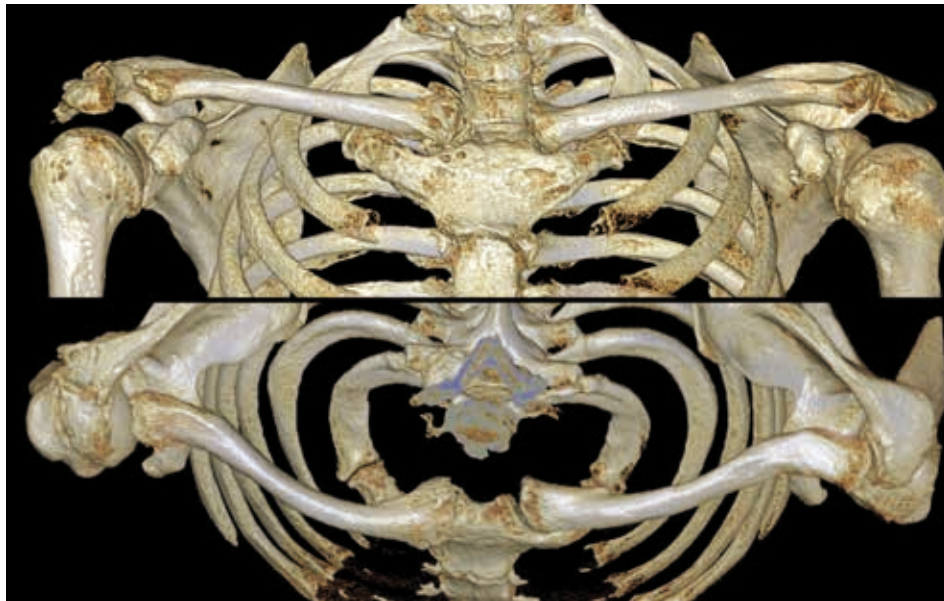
The case shown in Fig. 17-1, postoperative 3D CT reconstruction, with a clearly visible reduction of the SC joint.
